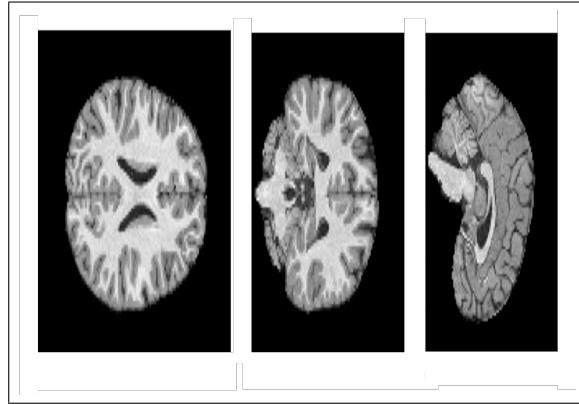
Examples of 3-dimensional T1-weighted neuroimaging input data. From left to right, horizontal section, coronal section, and midsagittal section of the brain anatomical image. The input size of 3-dimensional images are (96 x 96 x 96).
